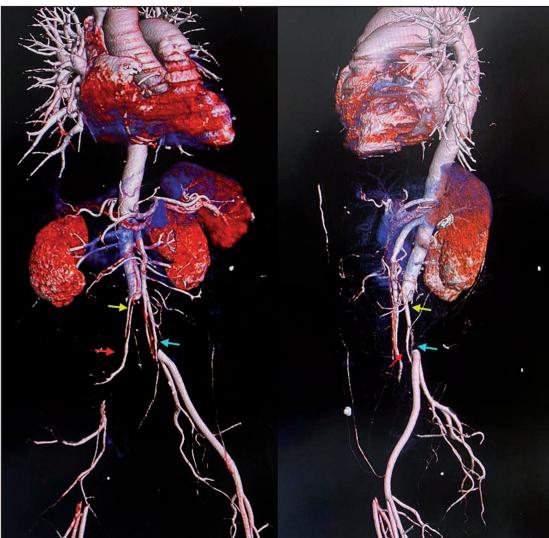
The computed tomography in the front view (left panel) and lateral view (right panel) revealed a near-total thrombus originating from the upper abdominal aorta at the level of the 3rd lumbar vertebrae with a distance of 2.6 cm from the bifurcation (yellow arrow), while nearly complete thrombi were observed in the right common iliac artery (red arrow), encompassing the right external iliac artery and the right internal iliac artery, as well as in the left common iliac artery (blue arrow).
